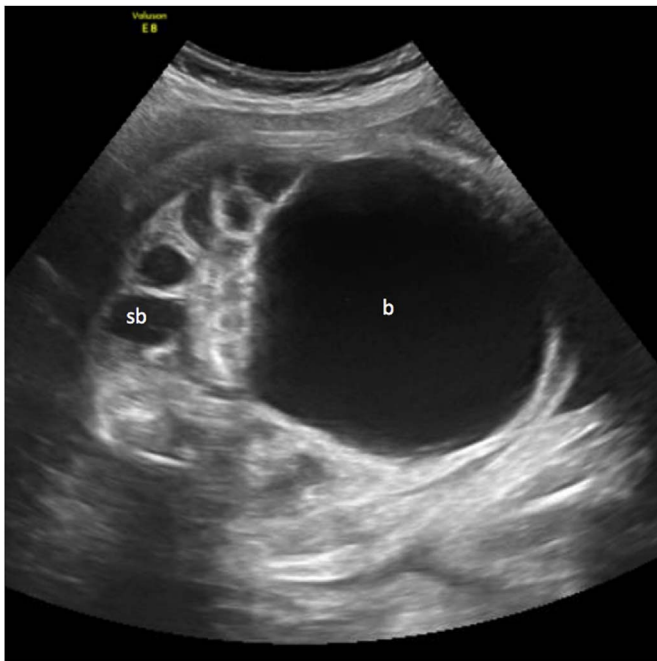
Prenatal ultrasound at 33 weeks showing megacystis (b) and dilated loops of small bowel (sb).
